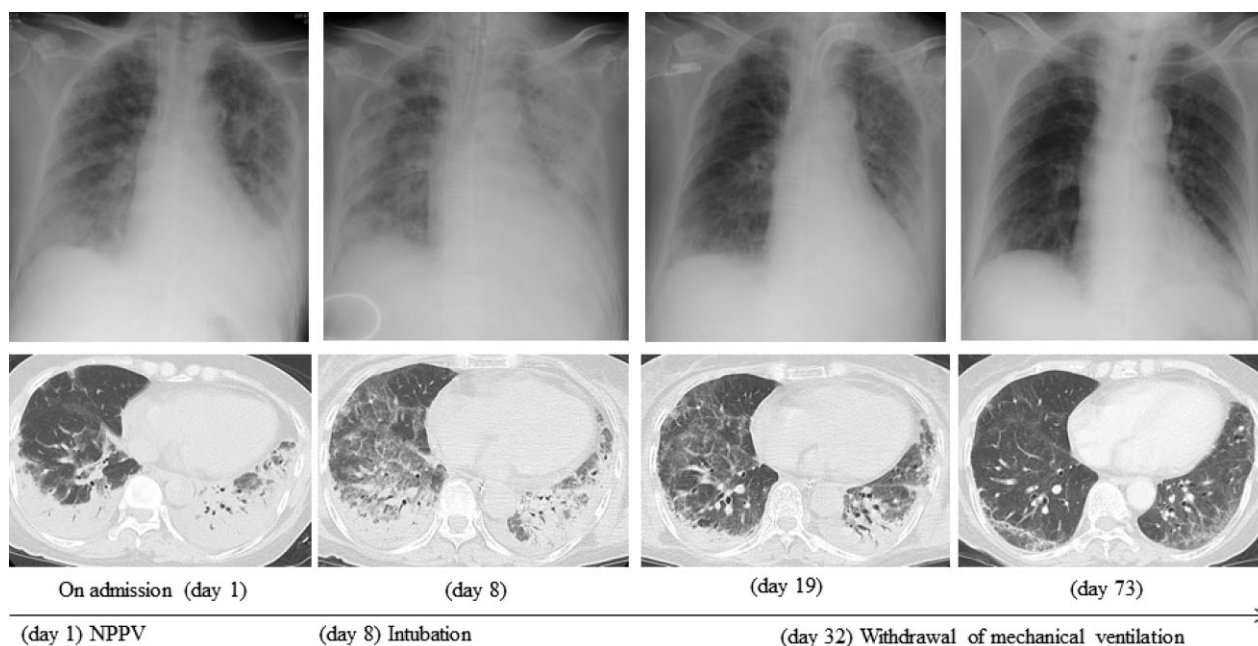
Clinical course as depicted by radiological imaging. Chest X-ray and computed tomographic images showed bilateral consolidations predominantly in the lower lobes at initial presentation (day 1). Deterioration was observed radiologically on hospital day 8, and intubation and mechanical ventilation were performed. Afterwards, the lesions had improved slightly by day 19, and mechanical ventilation was withdrawal on hospital day 32. Radiological improvement with no hypoxemia in the sitting position was observed on hospital day 73.
